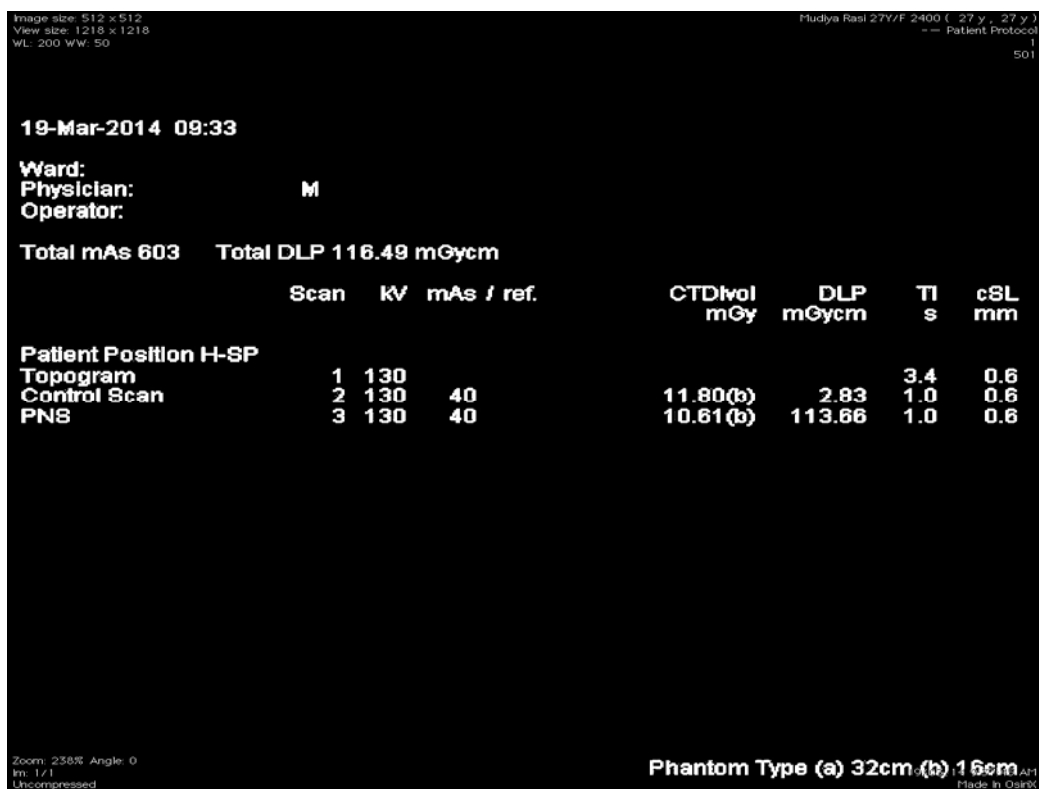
CT generated dose chart showing the dose length product (DLP)
